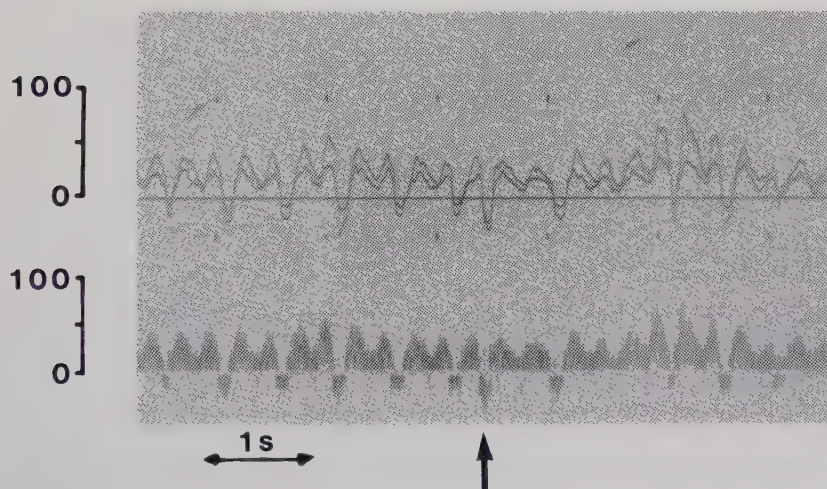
Premature atrial contraction (arrow) reflected in the blood velocity signals recorded from the fetal inferior vena cava. Doppler shift spectrum in the lower part; analogue signals of the estimated maximum and mean velocity in the upper part.
